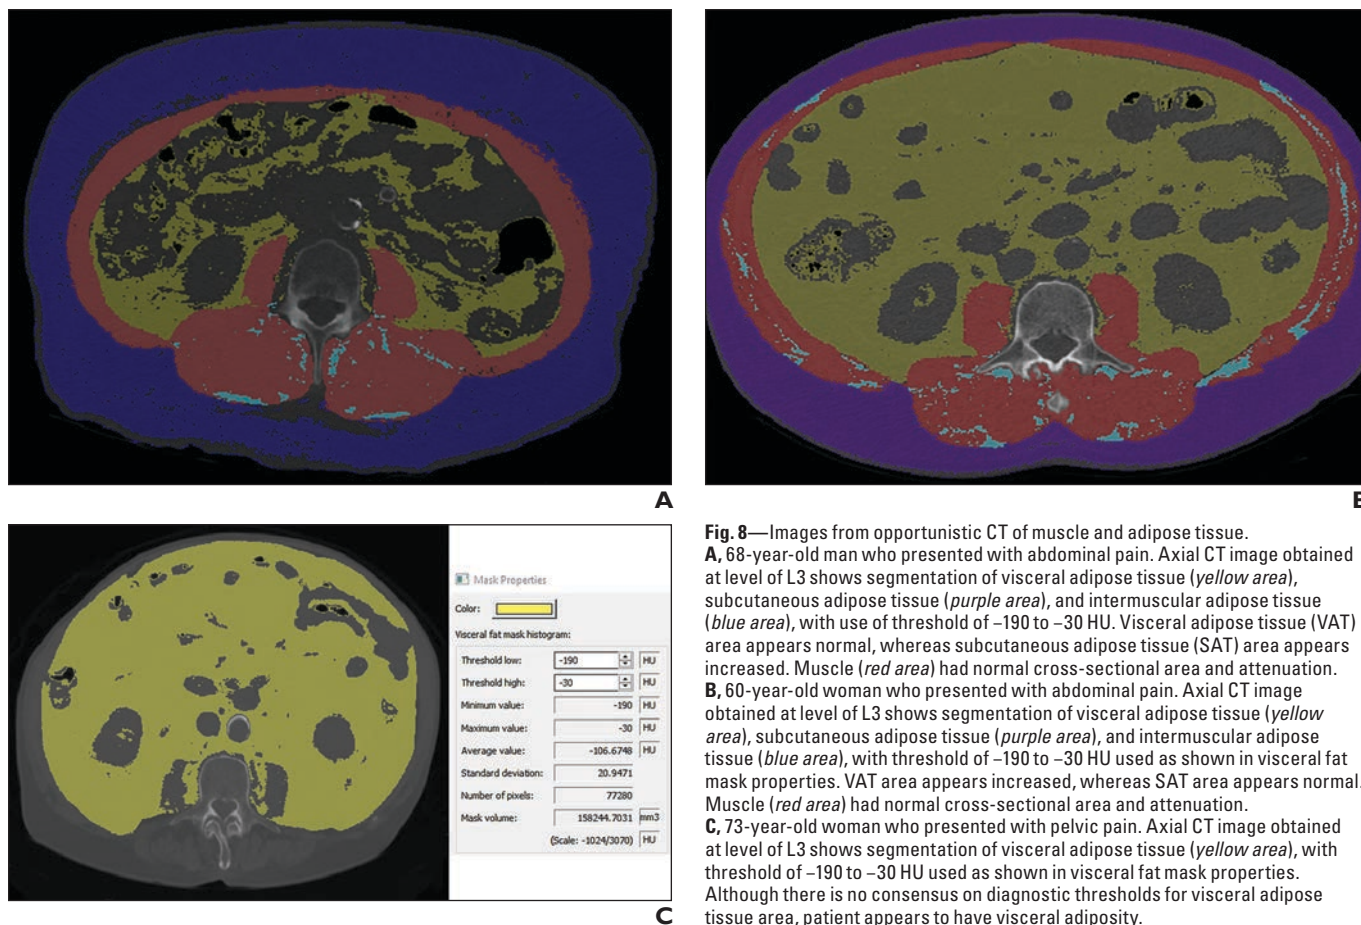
Images from opportunistic CT of muscle and adipose tissue. A, 68-year-old man who presented with abdominal pain. Axial CT image obtained at level of L3 shows segmentation of visceral adipose tissue (yellow area), subcutaneous adipose tissue (purple area), and intermuscular adipose tissue (blue area), with use of threshold of -190 to -30 HU. Visceral adipose tissue (VAT) area appears normal, whereas subcutaneous adipose tissue (SAT) area appears increased. Muscle (red area) had normal cross-sectional area and attenuation. B, 60-year-old woman who presented with abdominal pain. Axial CT image obtained at level of L3 shows segmentation of visceral adipose tissue (yellow area), subcutaneous adipose tissue (purple area), and intermuscular adipose tissue (blue area), with threshold of -190 to -30 HU used as shown in visceral fat mask properties. VAT area appears increased, whereas SAT area appears normal. Muscle (red area) had normal cross-sectional area and attenuation. C, 73-year-old woman who presented with pelvic pain. Axial CT image obtained at level of L3 shows segmentation of visceral adipose tissue (yellow area), with threshold of -190 to -30 HU used as shown in visceral fat mask properties. Although there is no consensus on diagnostic thresholds for visceral adipose tissue area, patient appears to have visceral adiposity.
